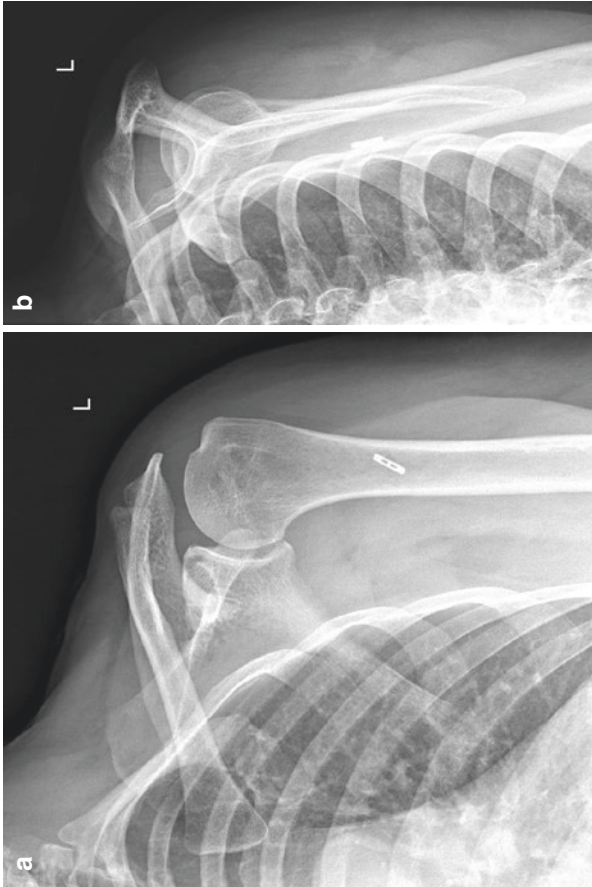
(a, b) Postoperative AP and trans thoracic lateral shoulder radiographs demonstrating acceptable positioning of unicortical biceps button (Arthrex, Naples, FL)
